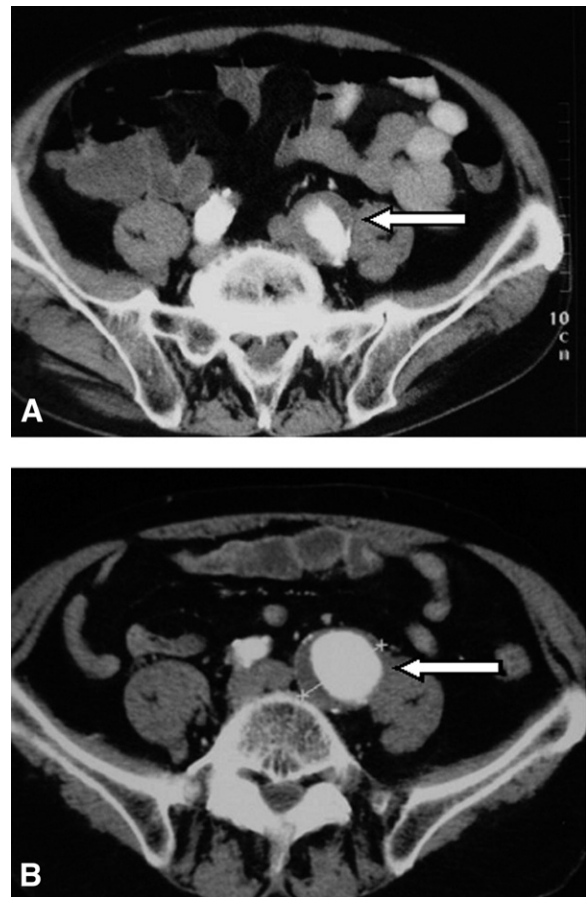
A, Left common iliac artery aneurysm (arrow) measuring 30 mm on the preoperative computed tomography scan. B, Four years after aortic tube-graft placement, the left common iliac artery aneurysm (arrow) measures 45 mm in diameter on the postoperative computed tomography scan.
